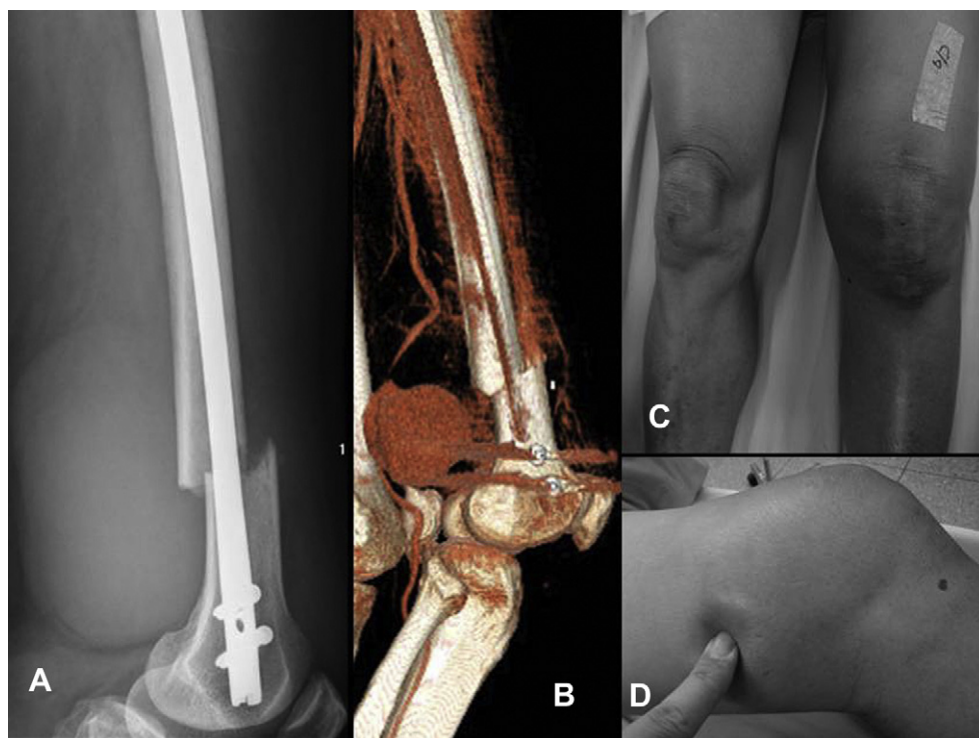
(A) Subsequent radiograph taken 6 weeks after fracture stabilization showing a well-defined enlarging soft tissue mass (13×8 cm in size) posterior to the distal femur; (B) reconstructed computed tomographic image demonstrating a huge vascular pouch originating from the adjacent superficial femoral artery behind the fracture site, cause vascular compression; (C) and (D) clinical photographs of progressive posteromedial thigh swelling.
